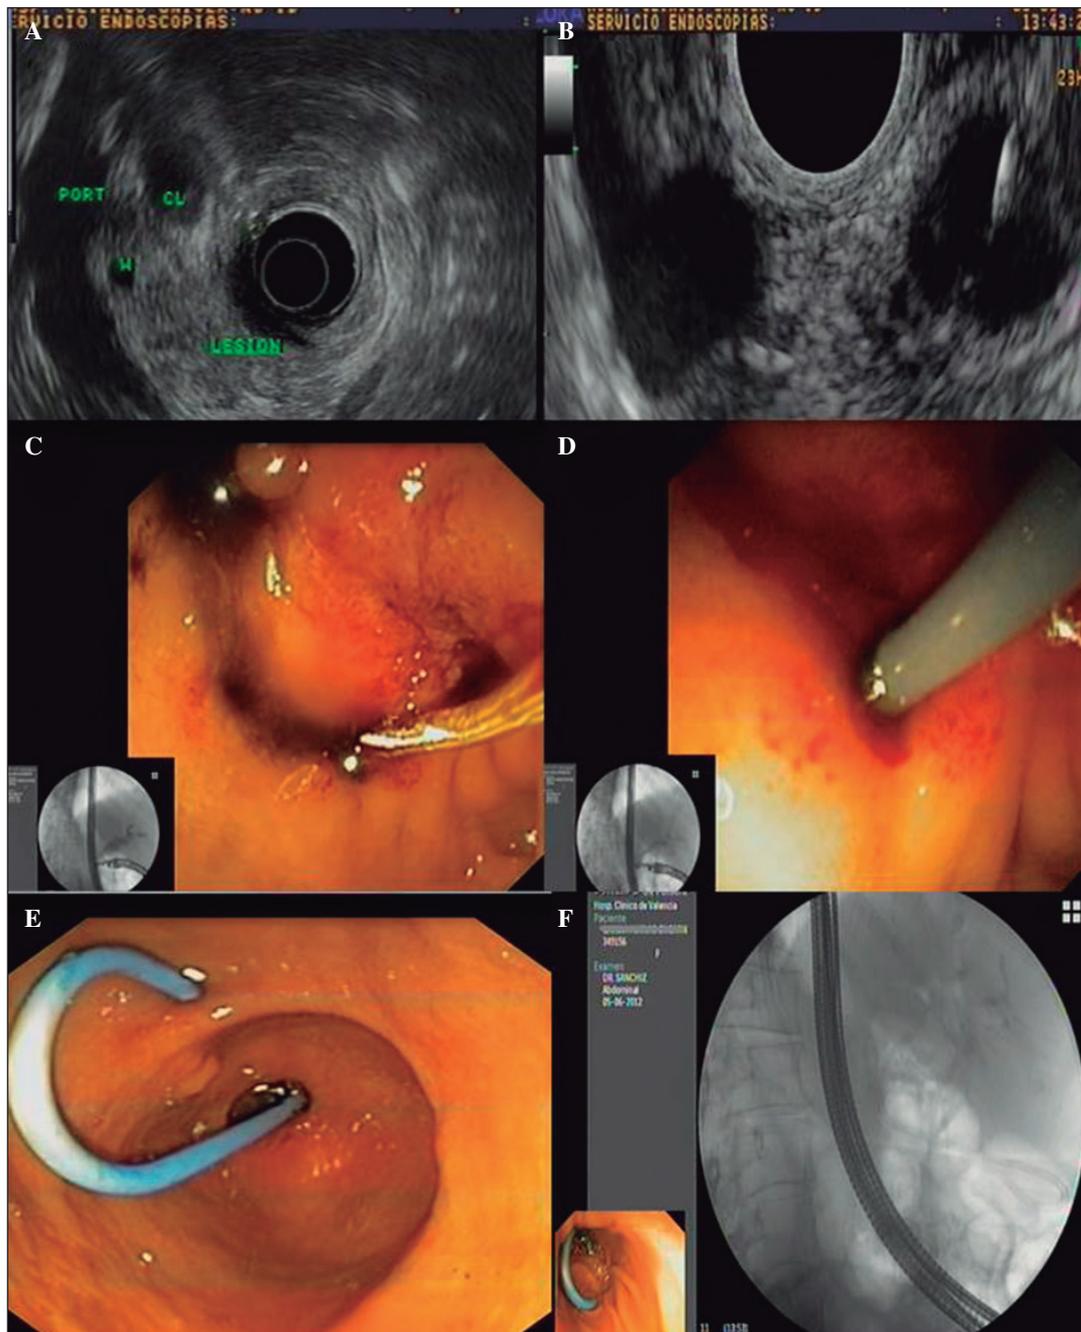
Endoscopic ultrasound-guided choledochoduodenostomy.
